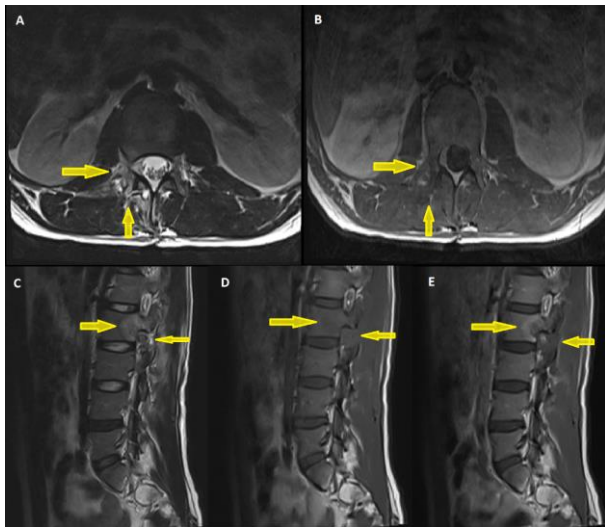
Sections showing that adequate decompression was achieved on postoperative contrast-enhanced lumbar MRI.
